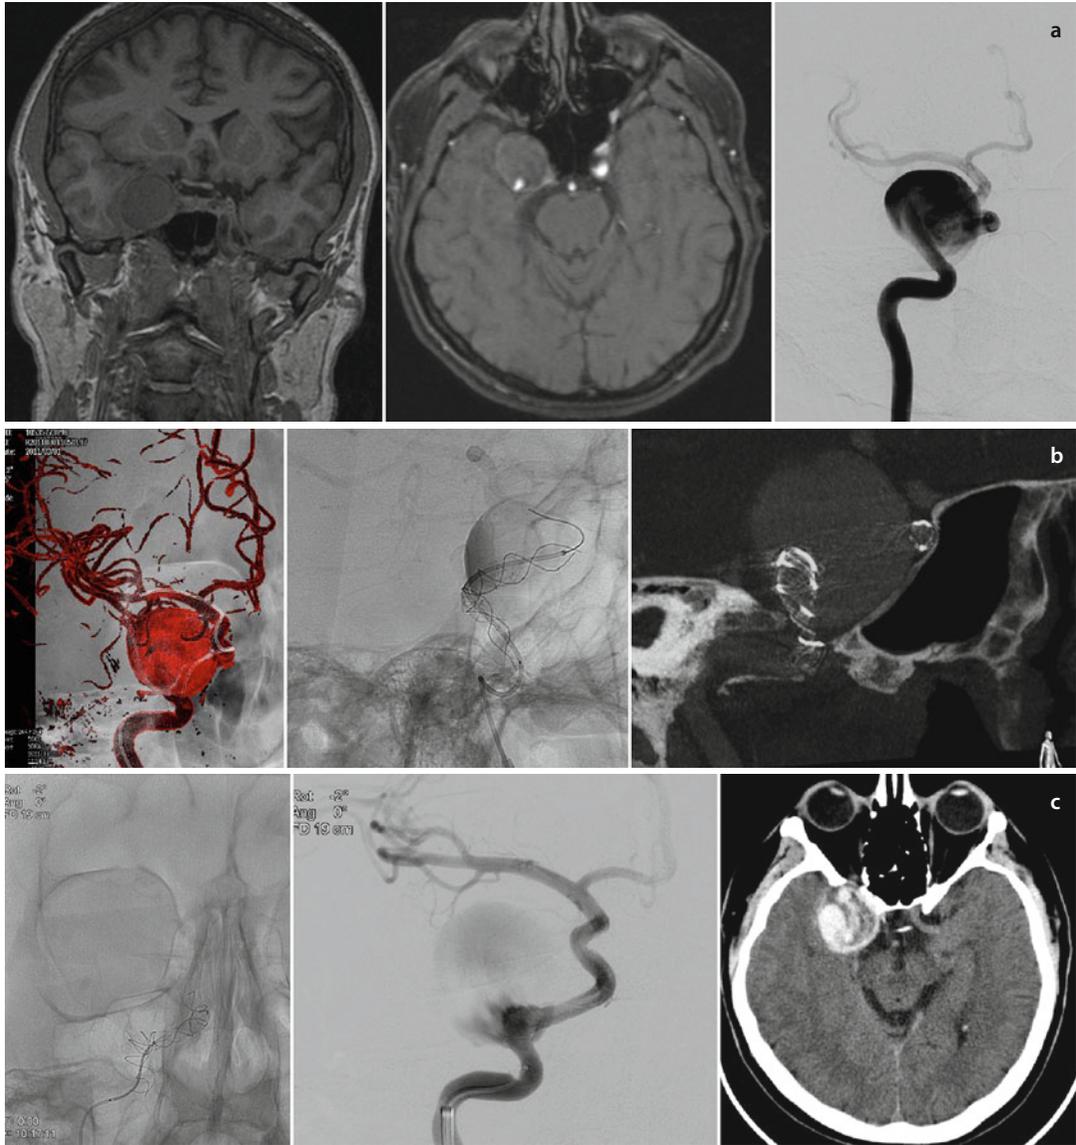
A 30-year-old man presented with retroorbital pain and ophthalmoplegia in 2011. (a) Coronal T1 MRI and axial TOF source images reveal a cavernous ICA aneurysm with indirect temporal lobe compression. There is no aneurysmal thrombosis or cerebral edema. Cerebral DSA reveals a giant sacculo-fusiform unruptured petro-cavernous aneurysm with a very wide neck demonstrating inflow zone at petro-cavernous junction. (b) On March 2011, using 3D road map imaging, a microcatheter was negotiated across the aneurysmal neck to the right MCA, and telescopic LEO[®] and SILK[®] flow diverters were deployed. On the second month follow-up, IV VASO CT[®] shows no aneurysmal sac thrombosis with partial coverage of inflow zone with an inner flow diverter. (c) After second telescopic SILK[®] deployment with further coverage of inflow zone, there was immediate intra-aneurysmal stasis (eclipse sign). NECT at 1 month after second treatment shows substantial aneurysmal thrombosis.
